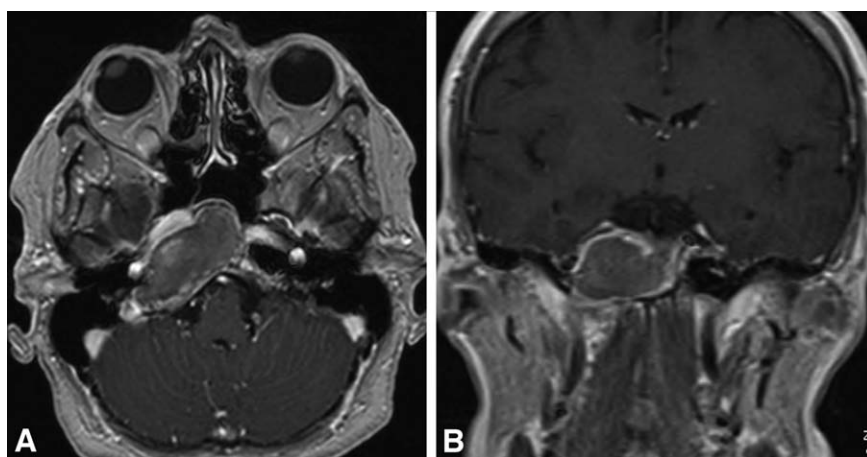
Preoperative magnetic resonance imaging (MRI) in the axial plane showing the right petrous apex lesion. (A) T1 with gadolinium: the lesion appears to be characteristically hyperintense with some areas of hypointensity within its content. (B) T1 with gadolinium: the lesion has the typical inflammatory MR pattern, as the enhancement appears to involve only the peripheral area of the lesion. This image shows also the close relationship between the mass and the internal carotid artery.
